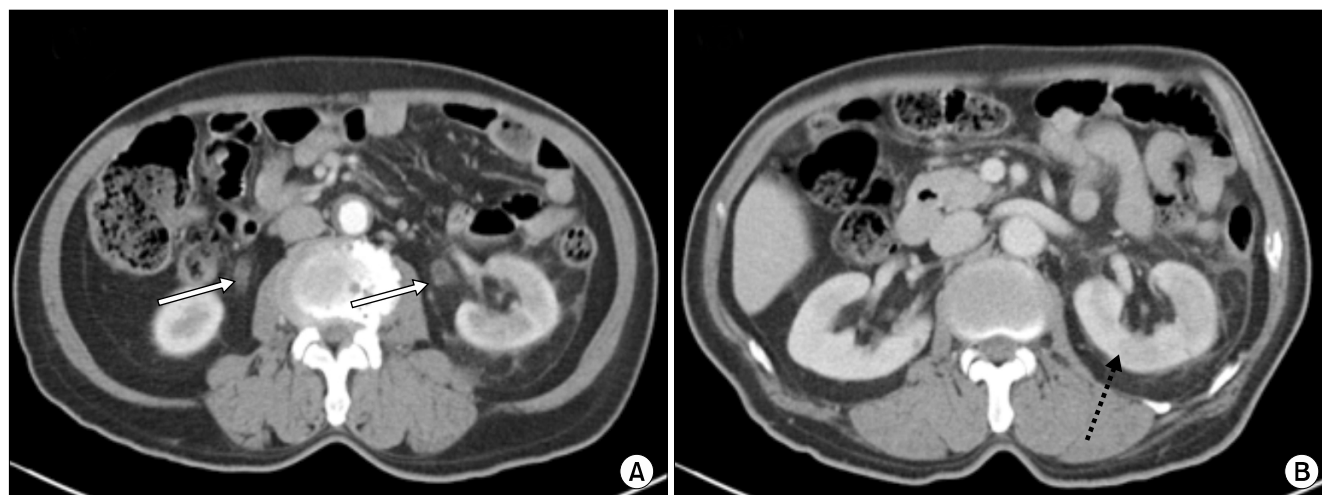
Computed tomography scans of the first patient. (A) Contrast-enhanced phase; prominent wall thickening and enhancement in both ureters (line arrows). (B) Delayed phase; multifocal wedge shaped poor enhancing lesion in the left kidney (dotted line arrow).
